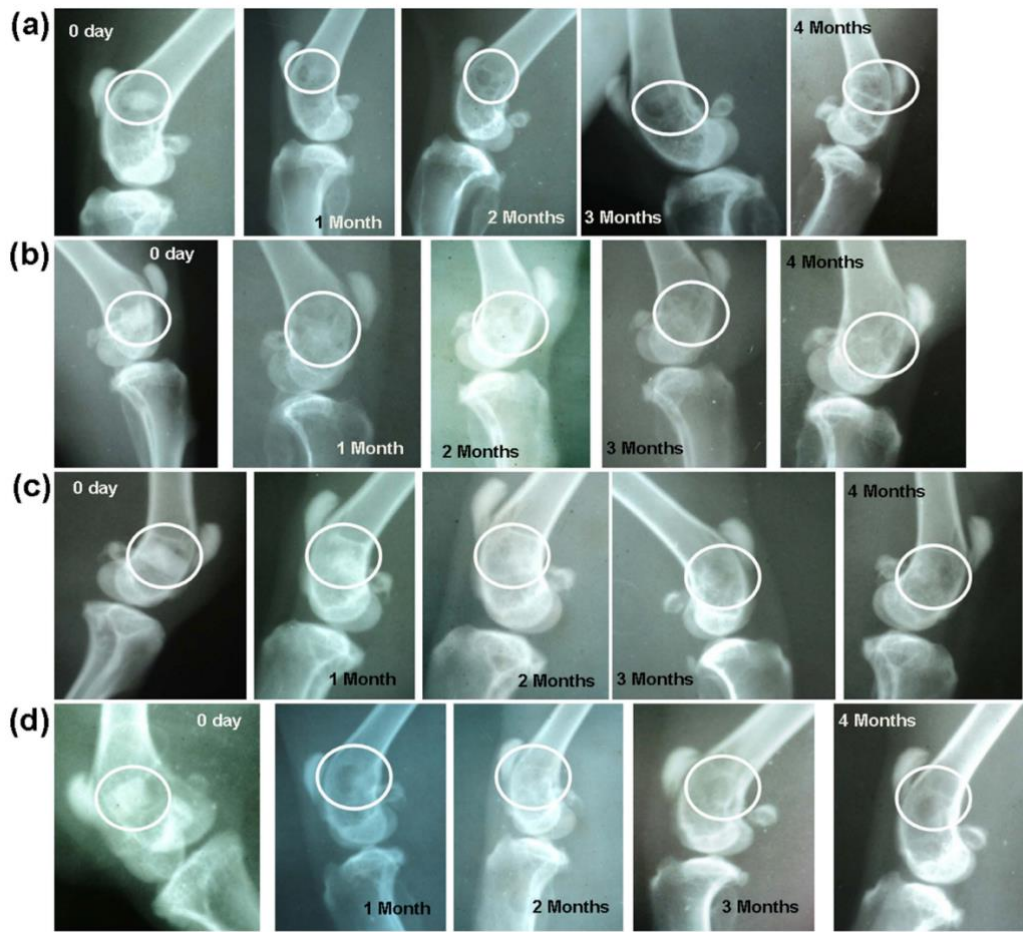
Radiographs taken at '0' day, 1, 2, 3 and 4 months post-operatively implanted with (a) BAG, (b) L-BAG, (c) S-BAG and (d) LS-BAG. Reproduced with permission from Khan et al. 2016⁵⁰ (Creative Commons Attribution License (CC BY)).
